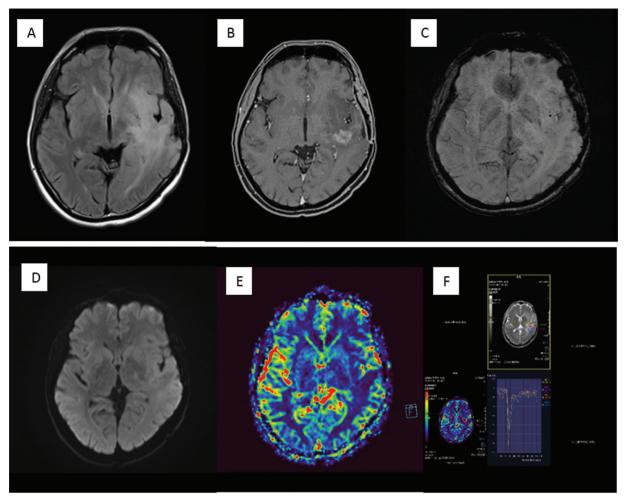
Post-treatment change in the form of radiation necrosis in a patient after resection of a higher-grade glioma followed by postoperative radiotherapy. (A) There is fluid-attenuated axial inversion recovery (FLAIR) hyperintensity surrounding the operative cavity. (B) There is heterogeneous "swiss-cheese" enhancement within. (C) On susceptibility-weighted imaging, there are multiple foci of blooming in the hyperintensity that most likely represent postradiotherapy cavernomas. (D) No restriction on diffusion-weighted imaging and (E, F) no elevated relative cerebral blood volume on perfusion imaging within the FLAIR hyperintensity and the enhancing area as compared with the contralateral side on perfusion color map and dynamic susceptibility contrast -curves.
